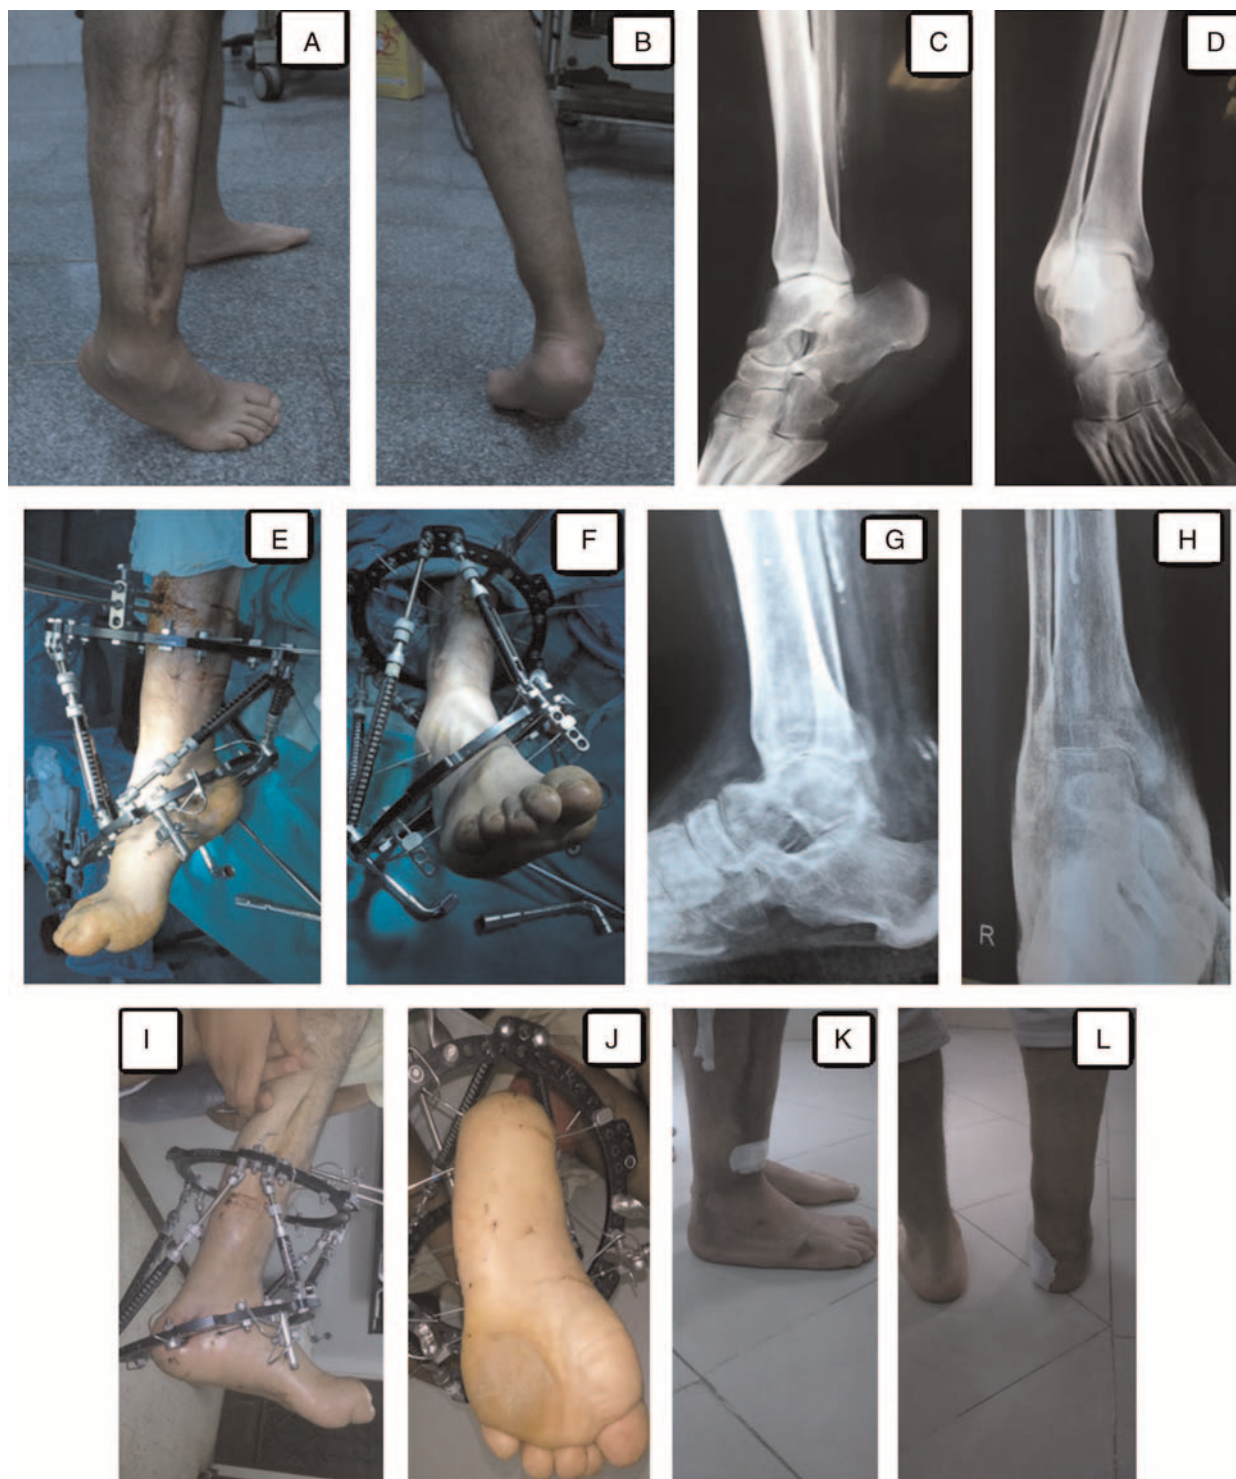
(A and B) A patient with Volkmann's ischemic contracture after tibial fracture with compartment syndrome. Clinical photographs of the scar from fasciotomy, the equinovarus deformity at the ankle joint. (C and D) Anteroposterior and lateral radiographs of the position of the ankle and the deformities. (E and F) Clinical photographs of the ankle and foot at the early stage of deformity correction by old version of Taylor Spatial Frame (TSF). (G and H) Anteroposterior and lateral radiographs of the ankle after full correction of the deformities. (I and J) Clinical photographs of the position of the ankle and foot at the final stage of deformity correction by TSF. (K and L) Clinical photographs after removal of the TSF and the short leg cast. The ankle became plantigrade.
